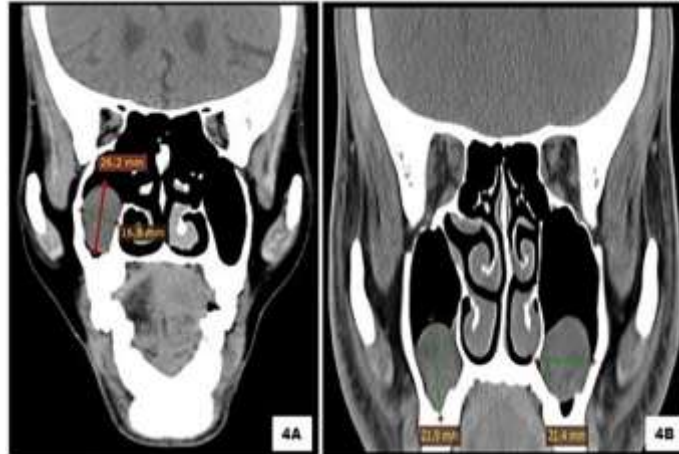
Morphological measurements (length and breadth) of maxillary sinus polyp on Computed Tomography scan - coronal view (Fig. 4A & 4B)
